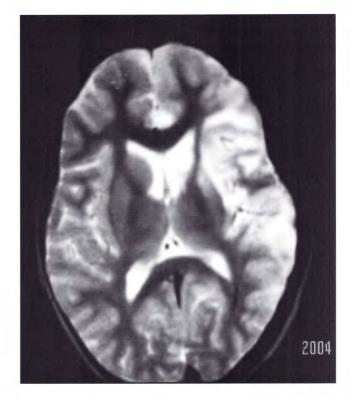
MRI: Typical image of a Rasmussen encephalitis 3 years progress of epilepsia partialis continua.
